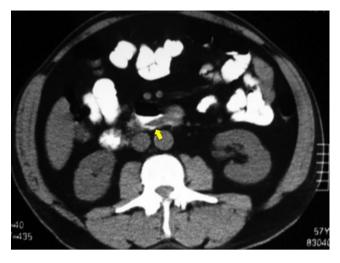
Duodenal diverticulum rupture. Unenhanced CT scan showing a ruptured diverticulum of the third portion of the duodenum. Oral contrast is out of the duodenal lumen outlining the outer wall of the duodenum, spreading into the retroperitoneum
